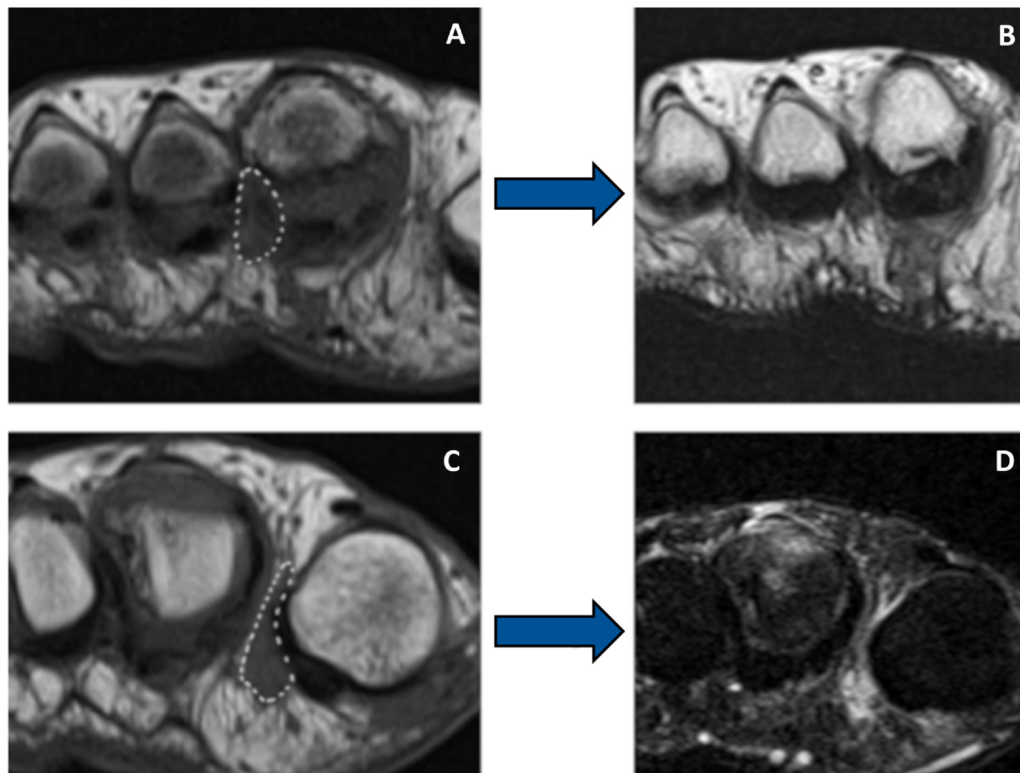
MRI findings. Morton's neuroma appears hypointense on both T1-weighted (A) and T2-weighted (B) sequences. Intermetatarsal bursitis is hypointense on T1-weighted images (C) and demonstrates characteristic hyperintensity on STIR sequences (D).
